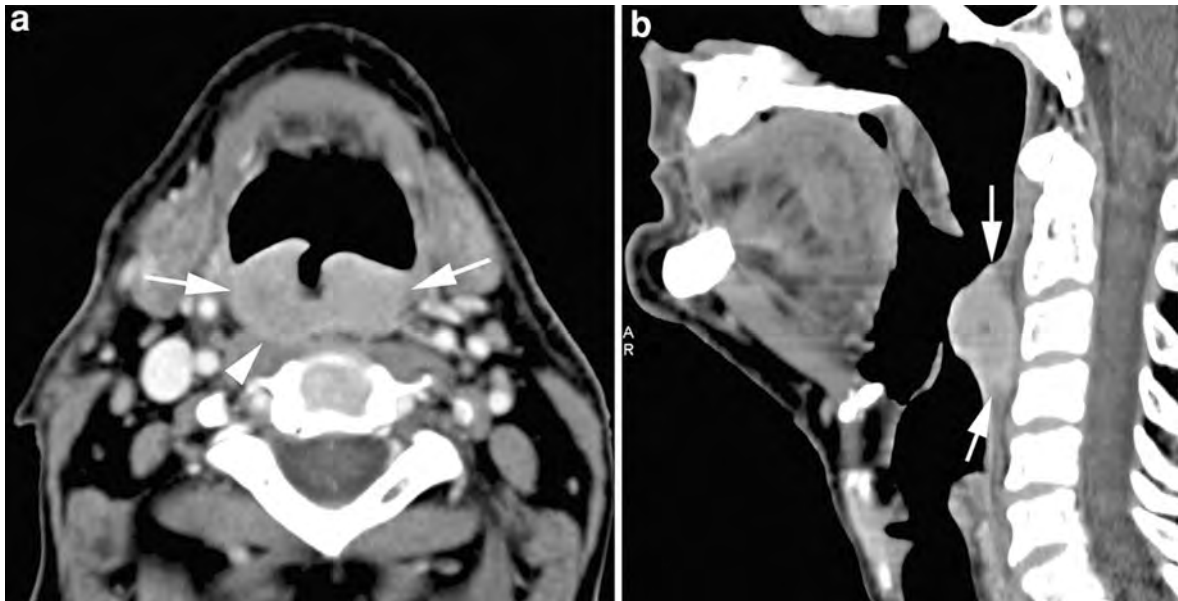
Contrast-enhanced CT-images in a patient with cancer of the posterior oropharyngeal wall. a Axial image. Contrast-enhancing soft tissue mass (*arrows*), showing ulceration. On the *right side*, the lesion obliterates the retropharyngeal fat plane and abuts the prevertebral muscle (*arrowhead*); invasion
